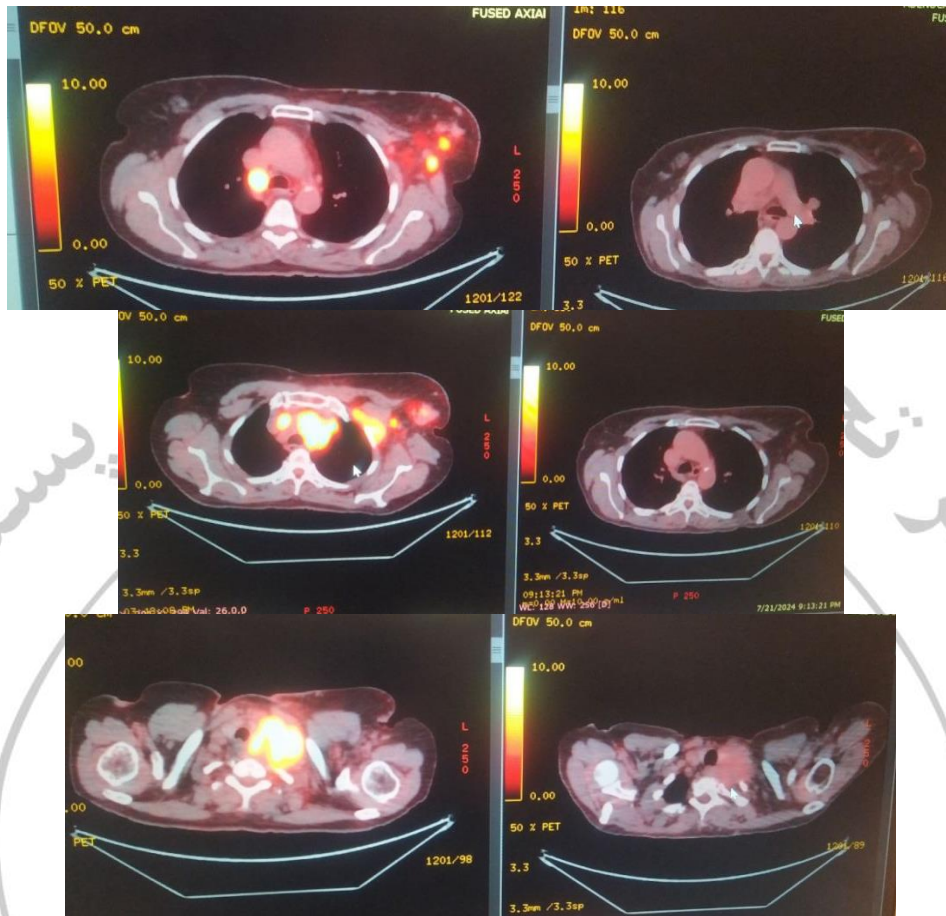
5 & 6: PET CT scan shows metastatic lesions was response to chemotherapy.
